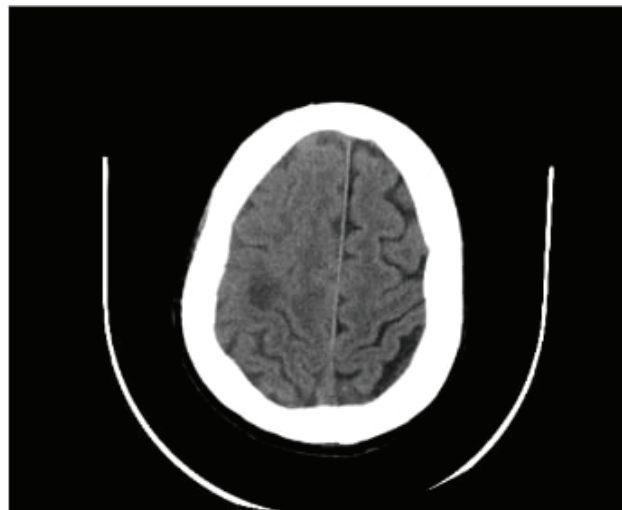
Non-enhanced CT shows a small hypodense lesion in the right frontal lobe.
